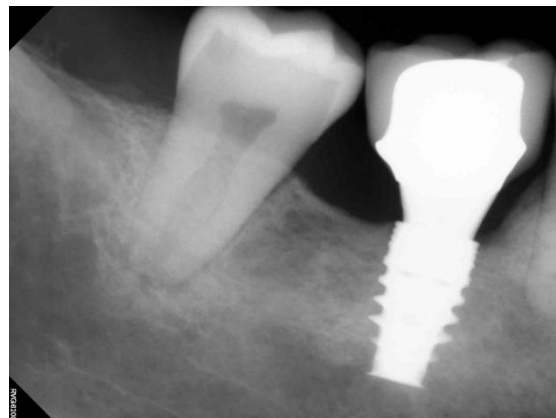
Intra-oral periapical radiograph showing implant fixture with restoration (6-month post-operative evaluation)
